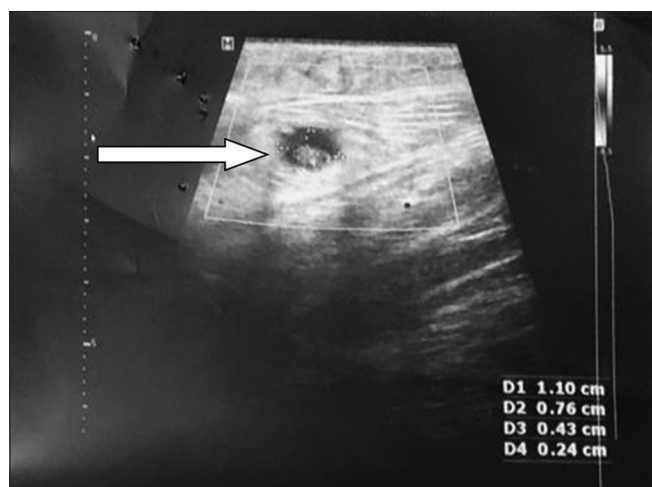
Ultrasound color Doppler lower limb
